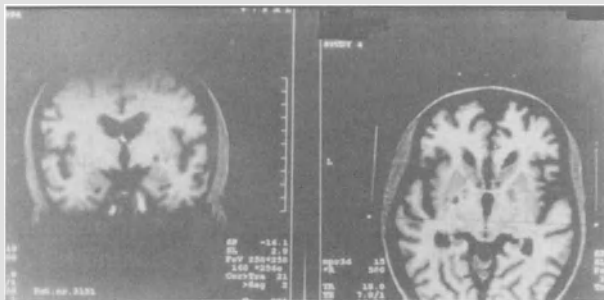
A stereotactic MRI study, performed 6 months after surgery. A 2 mm-thick axial slice and a 2 mm-thick coronal slice at the level of a left pallidotomy lesion are shown. The lesion lies at the ventralmost area of the posterior pallidum, just medial to the internal border of the putamen, just lateral to the external edge of the internal capsule, just above the dorsal amygdala, and lateral and dorsal from the ambient cistern and the optic tract. On the axial slice one can clearly see that the lesion encompasses both medial and lateral pallidum as these structures converge at the posteroventral aspects of the pallidum
